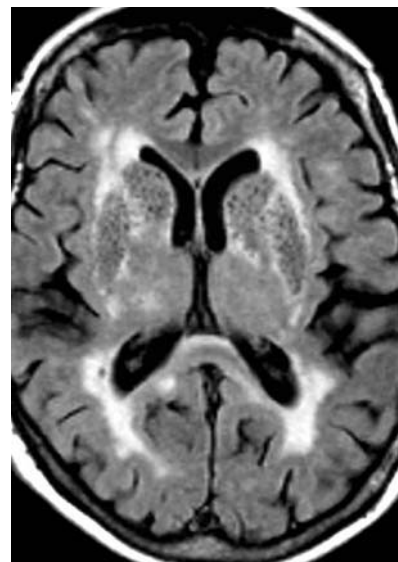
Coexistence of hyperintense white matter lesions (WML), and diffusely widened enlarged hypointense VRS (so-called état criblé) on a CSF-suppressed transverse MR image.
